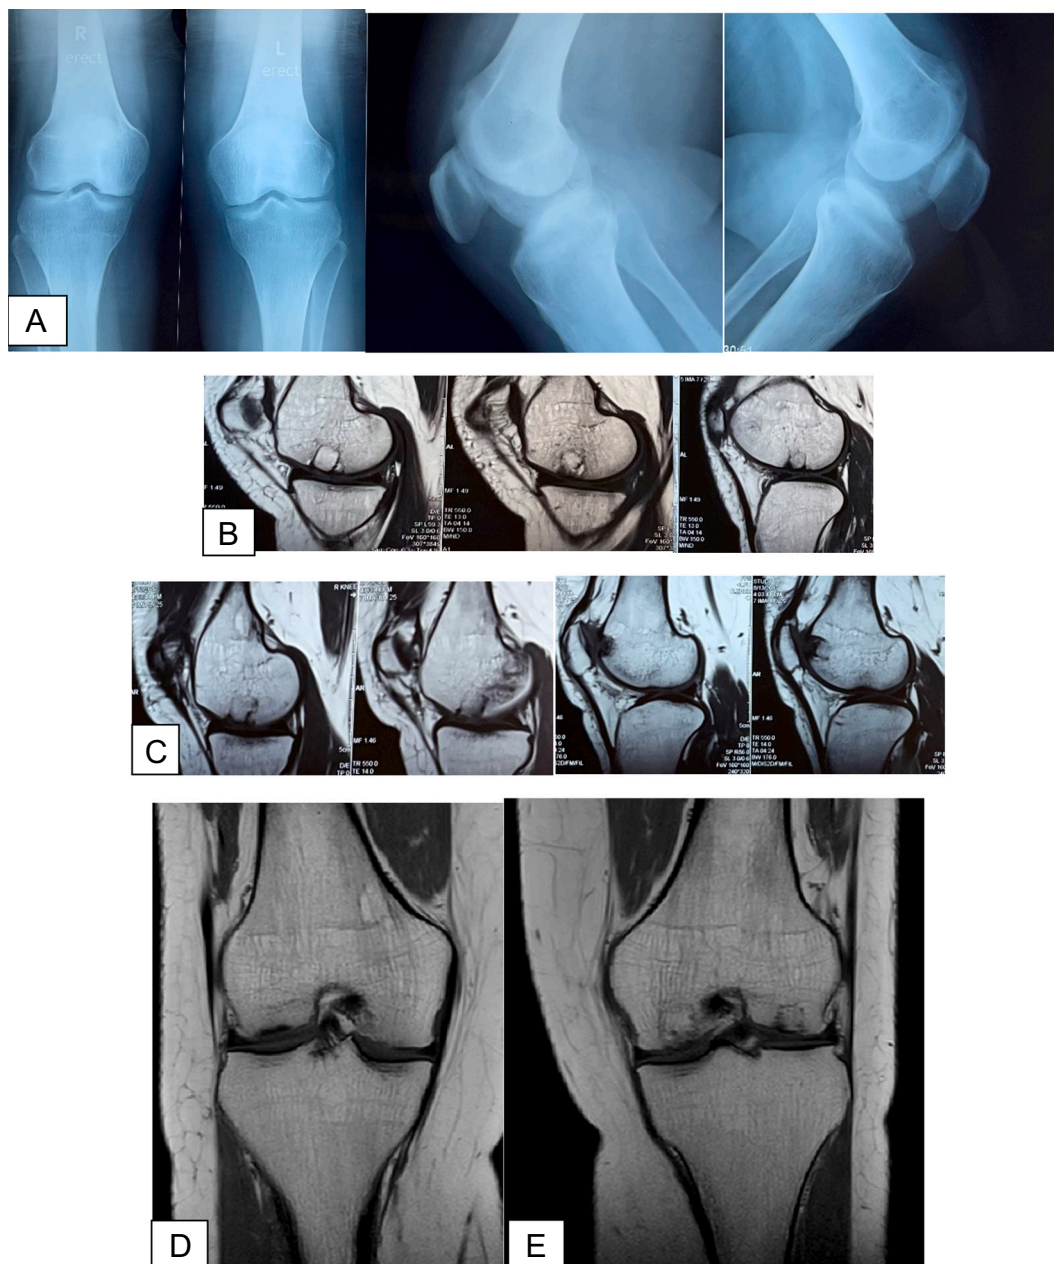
A: plain X-ray one year postoperatively, B: MRI of the left knee one year postoperatively, C: MRI of the right knee one year postoperatively, D: MRI of the right knee five years postoperatively, E: MRI of the left knee five years postoperatively.
